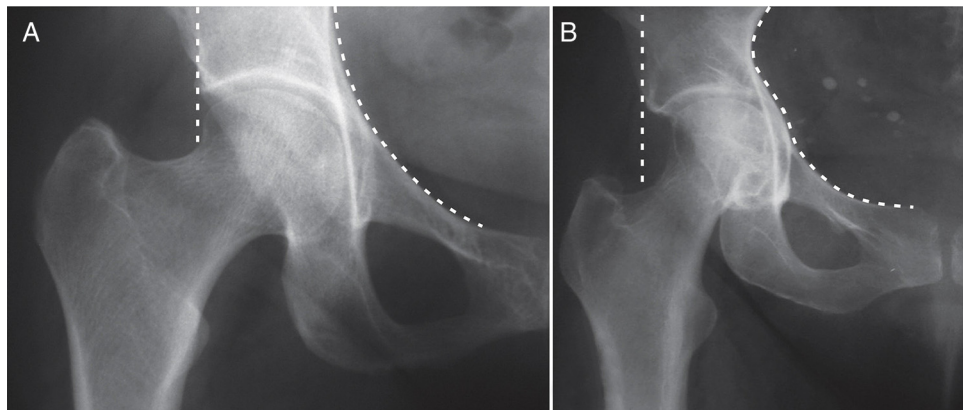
X-rays in cases of coxa profunda (A) and protrusio acetabula (B). In the latter case, the cephalic entrapment is more severe and there is a bulging in the iliopubic line.
